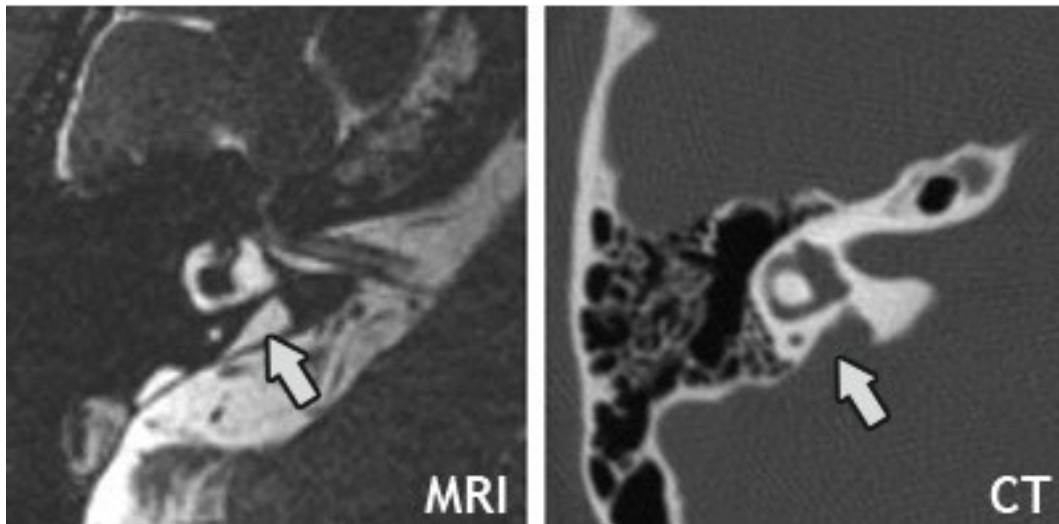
Temporal bone imaging in enlarged vestibular aqueduct — MRI (left) and CT (right) demonstrating the enlarged vestibular aqueduct (arrows) in the same patient. CT defines the bony canal; MRI delineates the endolymphatic duct and sac.
